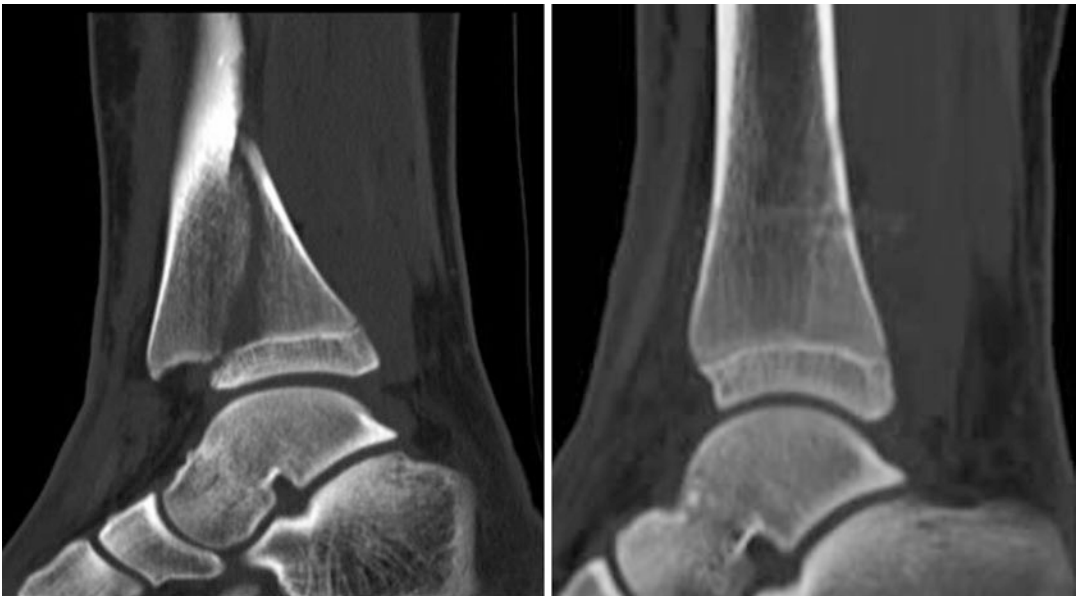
X-rays of distal tibia fracture. Reduction and fixation with biodegradable screws
